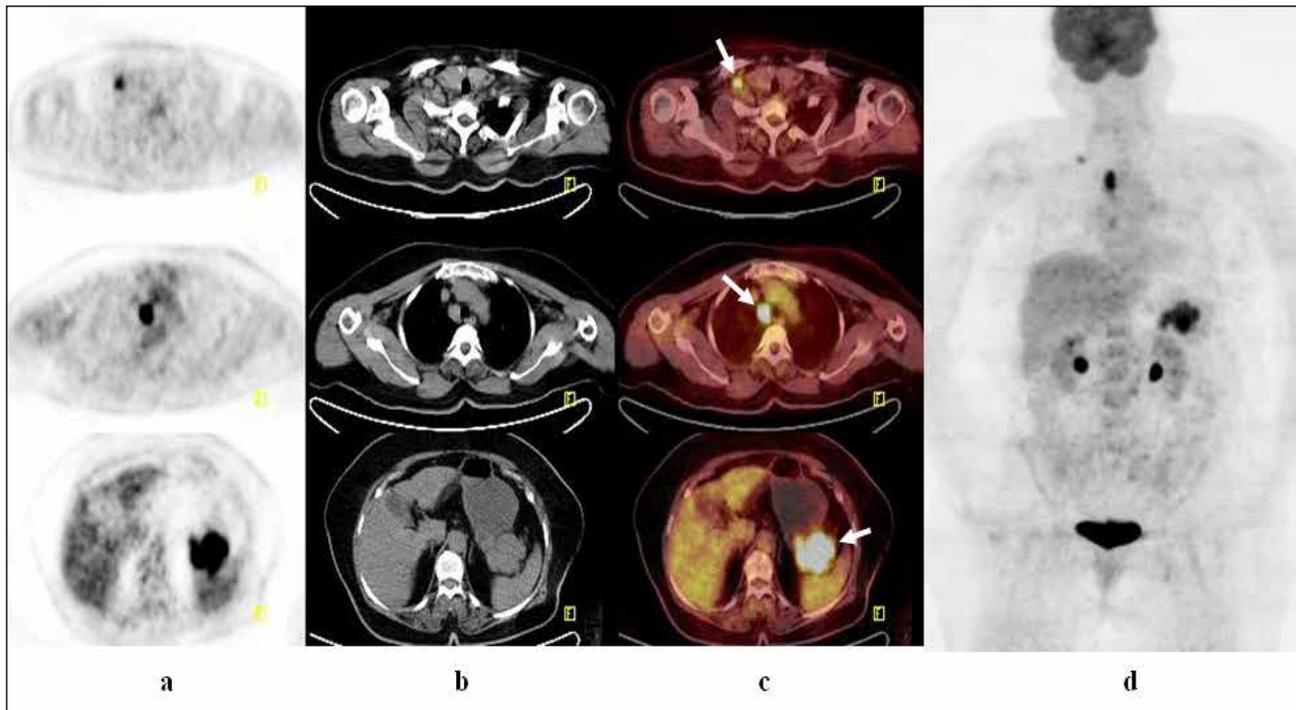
(a,b,c,d) F-18 FDG PET, CT, PET/CT fusion and PET MIP images in the patient with sarcoidosis
